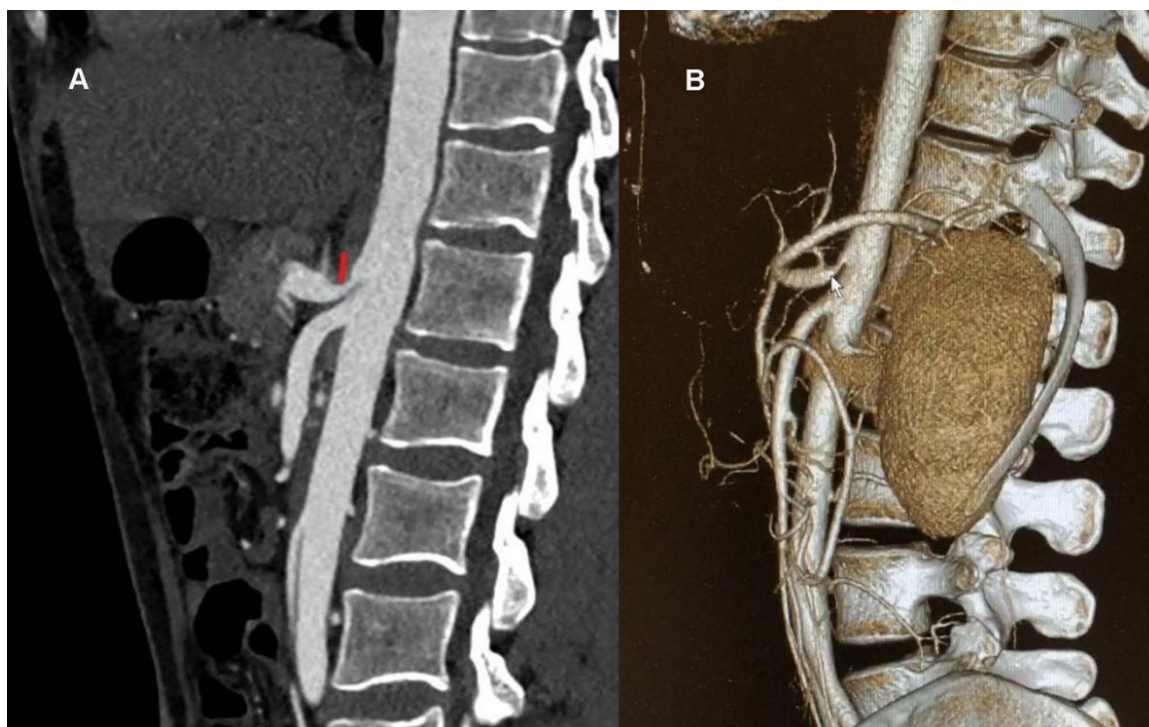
(A) Computed tomography angiography, sagittal view of aorta and celiac artery (CA) in a patient with MALS; redline points at the CA artery stenosis caused by the median arcuate ligament. (B) Three-dimension reconstruction of the CA stenosis due to external compression. The arrow points at the CA stenosis and the post-stenotic dilatation.
